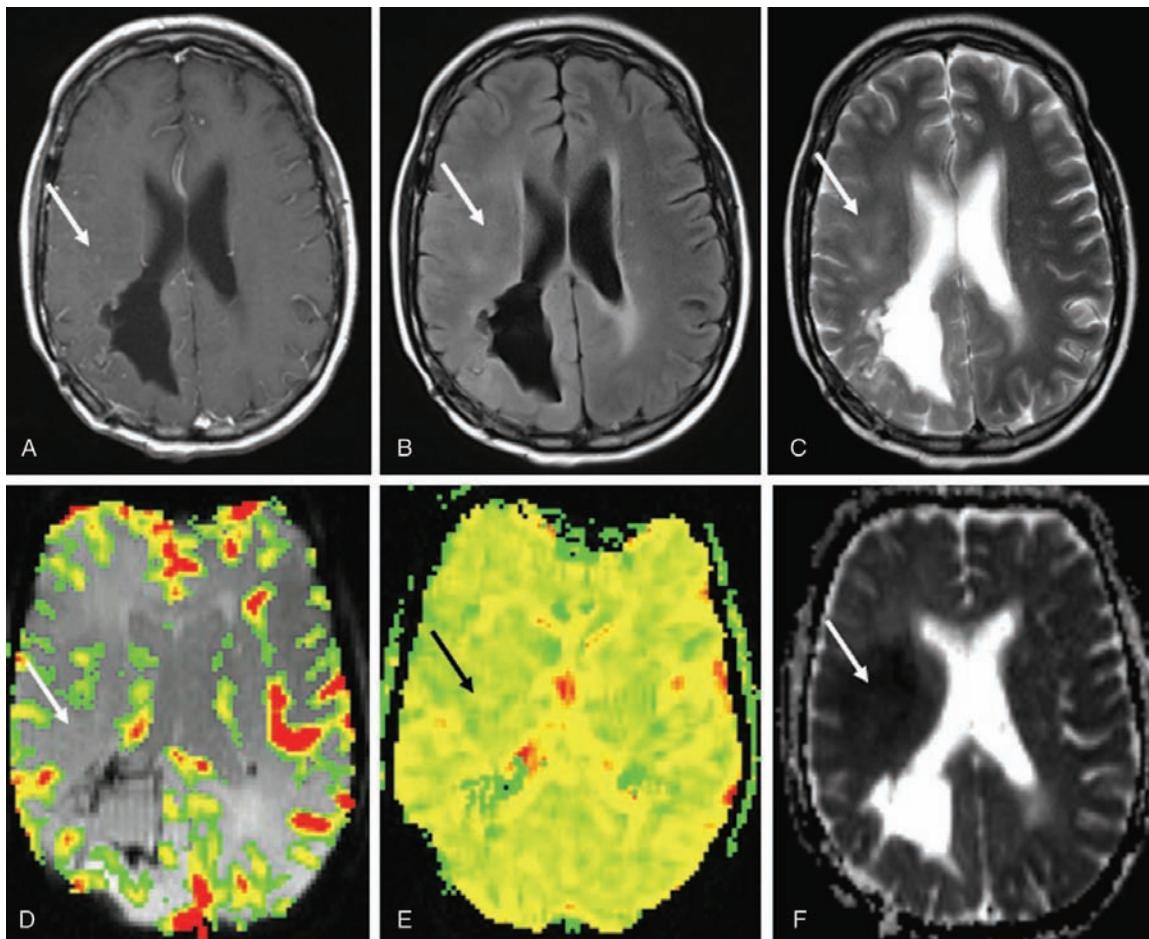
Pathologically recurrent glioblastoma multiforme, the same patient as in Figure 25 following two months of therapy with Avastin. (A) Axial T1-weighted post-gadolinium image. (B/C) Axial FLAIR and T2-weighted images demonstrating radiographic response to antiangiogenesis therapy, Avastin. There is almost complete resolution of contrast enhancement as well as associated T2 signal abnormality (white arrows). (D) Gradient-echo axial DSC MRI with rCBV color overlay demonstrates reduction in rCBV within the lesion (white arrow). (E) Gradient-echo axial DSC MRI with SD25 color overlay depicts signal intensity drop after 25 seconds, indicating decreased vascular permeability (black arrow). These findings are in keeping with a decrease in perfusion and permeability in response to Avastin therapy. (F) Diffusion-weighted ADC image demonstrates further decrease in signal, suggesting possible increase in tumor cellularity and possible invasiveness within the recurrent glioma, which may be a biologic response to the removal of the angiogenic component. Abbreviations: FLAIR, fast fluid-attenuated inversion recovery; DSC MRI, dynamic susceptibility contrast MRI; rCBV, relative cerebral blood volume; ADC, apparent diffusion coefficient.
